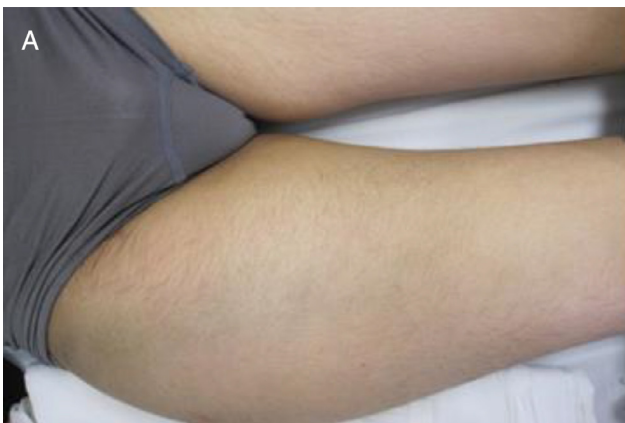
(A) Initial clinical image of the patient showing volume increase in the upper thigh; (B) radiographic image of the pelvis on admission to hospital.
